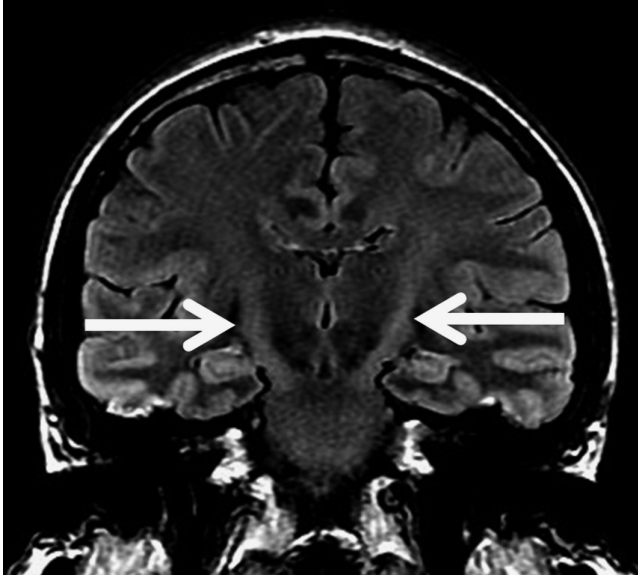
Hyperintensity of the corticospinal tracts in MND was one of the first observations made on MRI, but it is neither sensitive nor specific enough to be a biomarker. This coronal MRI (tracts marked with arrows) was undertaken in an apparently healthy individual.
